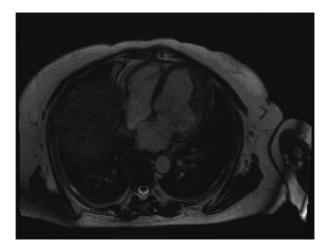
Magnetic Resonance Image showing steady state free precession showing increased thickness of lateral wall [mid/apical segments] with irregular endomyocardial contour.
